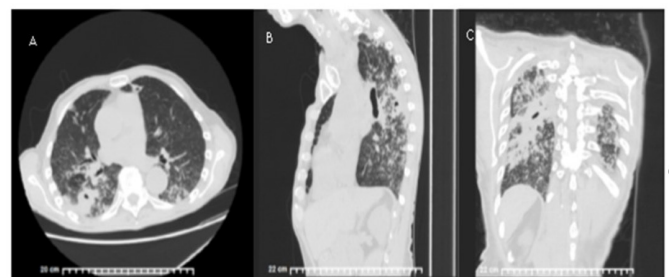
(A) CT thorax with (B) sagittal and (C) coronal views showing a large cavitary spiculated mass seen in the dependent portion of the superior aspect of the right lower lobe with surrounding subcentimeter branching centrilobular nodules.
